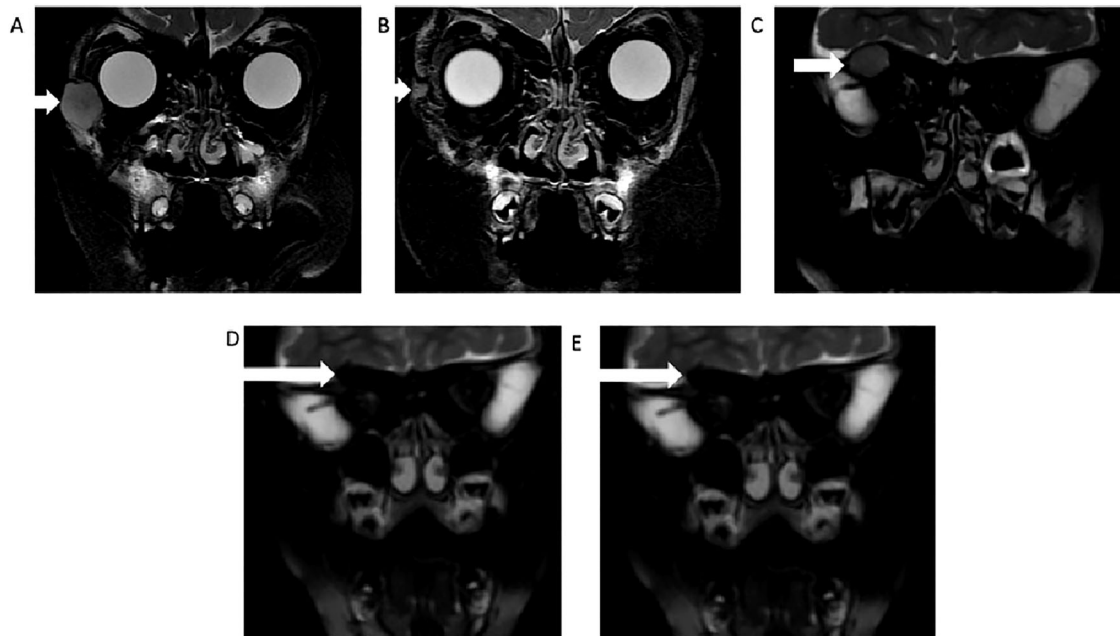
MRI of Individual 2: evolution of right orbital myofibroma before and under treatment. A Arrow : Right orbital myofibroma before treatment, dimensions approximately 20 × 13 mm 33 months before the therapy started. B Arrow : Myofibroma after surgery alone 26 months before the therapy started. C Arrow: Myofibroma relapse 18 months post-surgery, 11 months before the therapy started. D. Arrow : Myofibroma after 7 months of sunitinib. E Arrow: Myofibroma after 35 months of TKIs.
